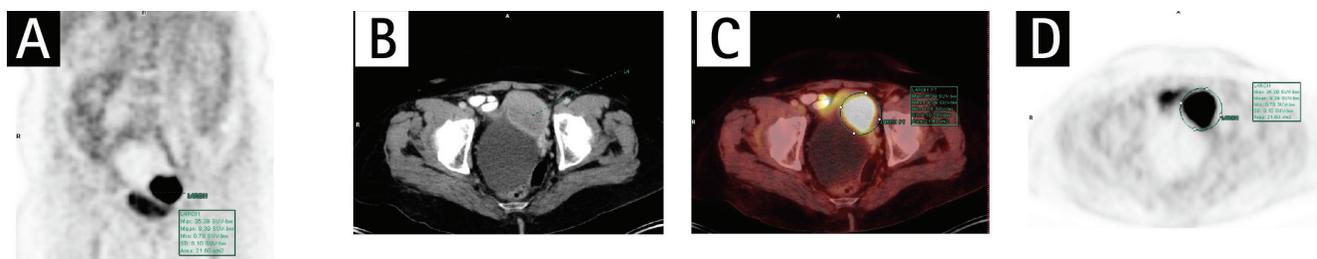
Maximum standardized uptake value of the primary tumor was measured 35,39. Endometrioid type endometrial carcinoma (grade 2, International Federation of Gynecology and Obstetrics stage 3A). A) Maximum intensity projection image. B) Transaxial computed tomography image. C) Transaxial positron emission tomography+computed tomography fusion image. D) Transaxial positron emission tomography image of the primary tumor
